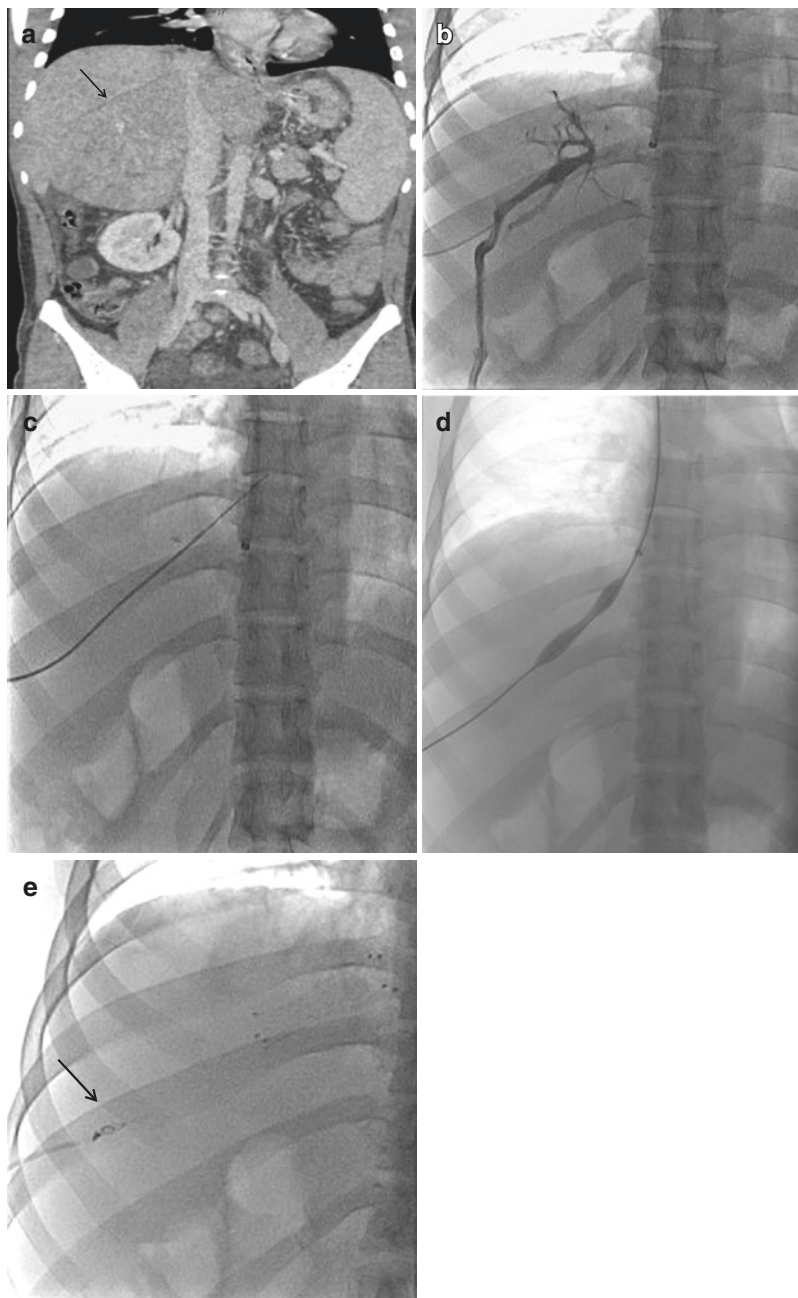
Contrast enhanced CT image (a) shows thrombosed right hepatic vein (black arrow). Venogram performed through percutaneous hepatic venous access (b) shows short segment occlusion of hepatic venous ostium with veno-venous collaterals. Guide wire negotiated through the stenotic segment (c) and advanced in the IVC and snared through the right internal jugular access. Balloon dilatation of the occluded segment done via jugular access (d). Stent was deployed across the occluded segment of hepatic vein with embolization of percutaneous tract by coils (e) (black arrow)
